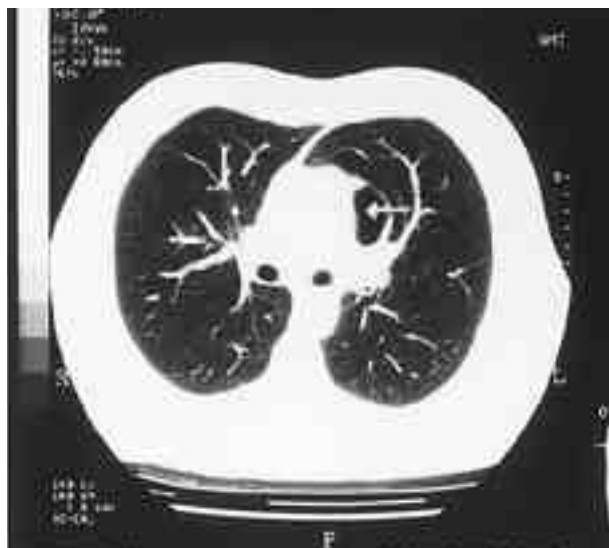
CT scan showing a circumscribed air filled loculus (arrow) in the middle mediastinum in close proximity to pericardium and left main pulmonary artery
